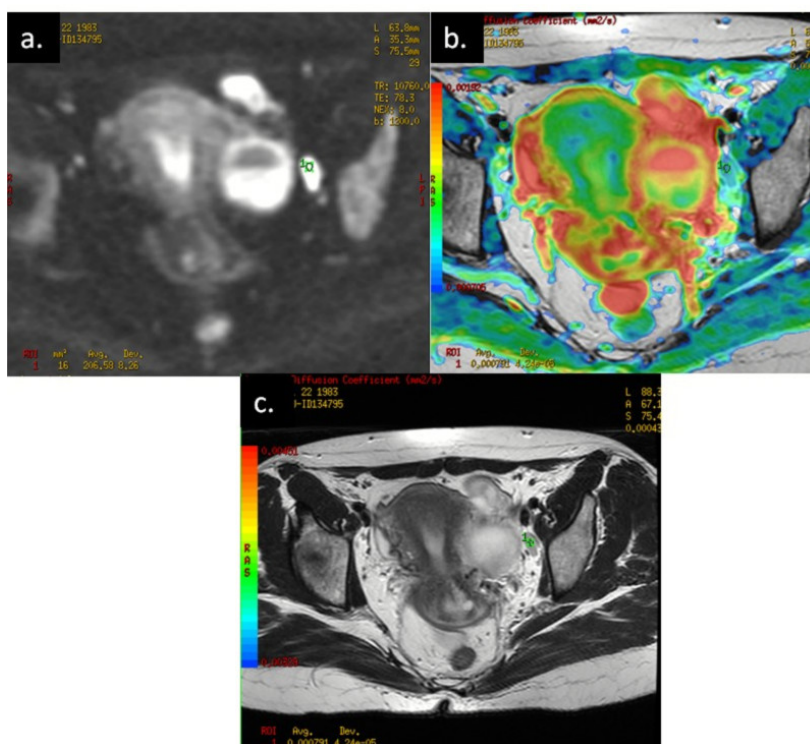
A 33-year-old-patient with serous cystadenocarcinoma of the left ovary, the International Federation Gynecology and Obstetrics (FIGO) stage IIIC. Metastatic enlarged external iliac lymph node with restricted diffusion: a) axial high b-value diffusion-weighted imaging (DWI); b) fusion of apparent diffusion coefficient (ADC) map and axial T2W; c) axial T2W.
